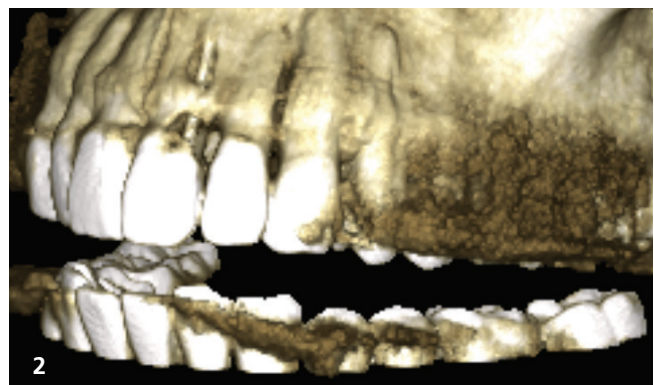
Pre-op clinical image showing the affected teeth #11 and 21. Fig. 2: CBCT evaluation showing fenestration at tooth #21.
